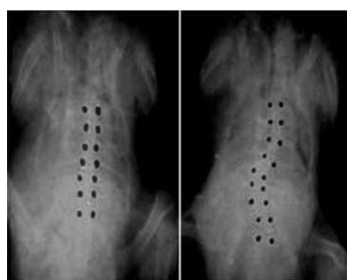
Radiography of normal and scoliotic pinealectomized chicken.
